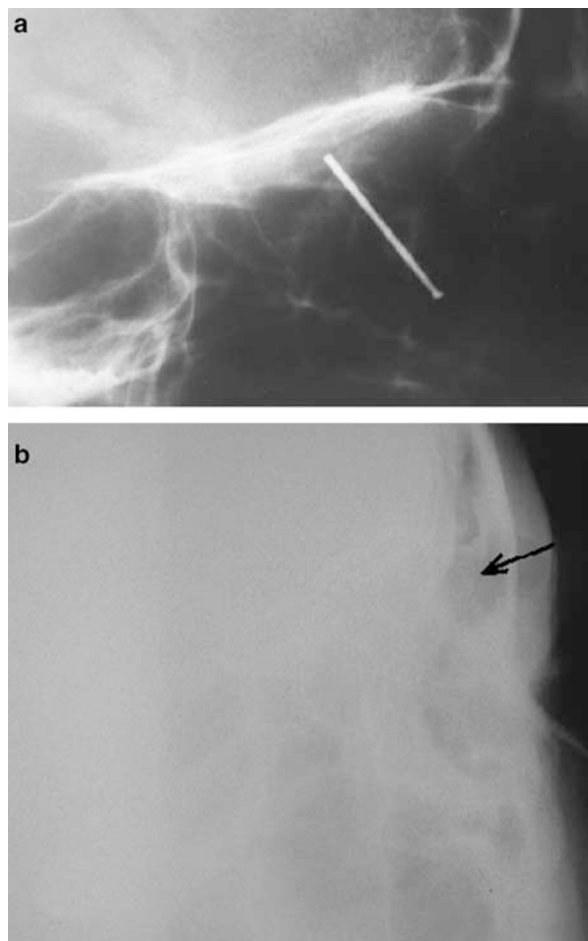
(a and b) Lateral orbital radiograph showing the nail in close proximity to the superior orbital roof (a) and surgical emphysema in the upper lid (b; arrow).
